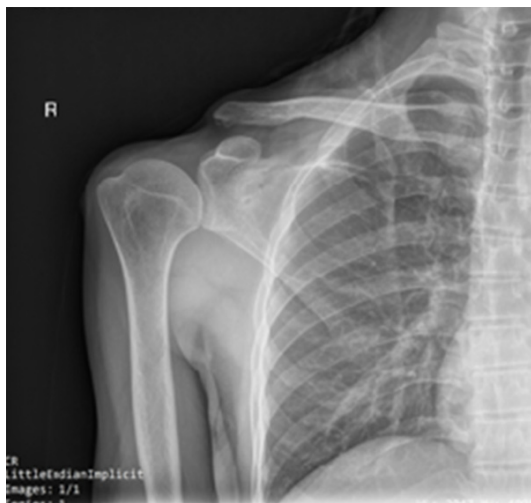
2 year post-operative follow-up radiograph showing no sign of re-occurrence.
